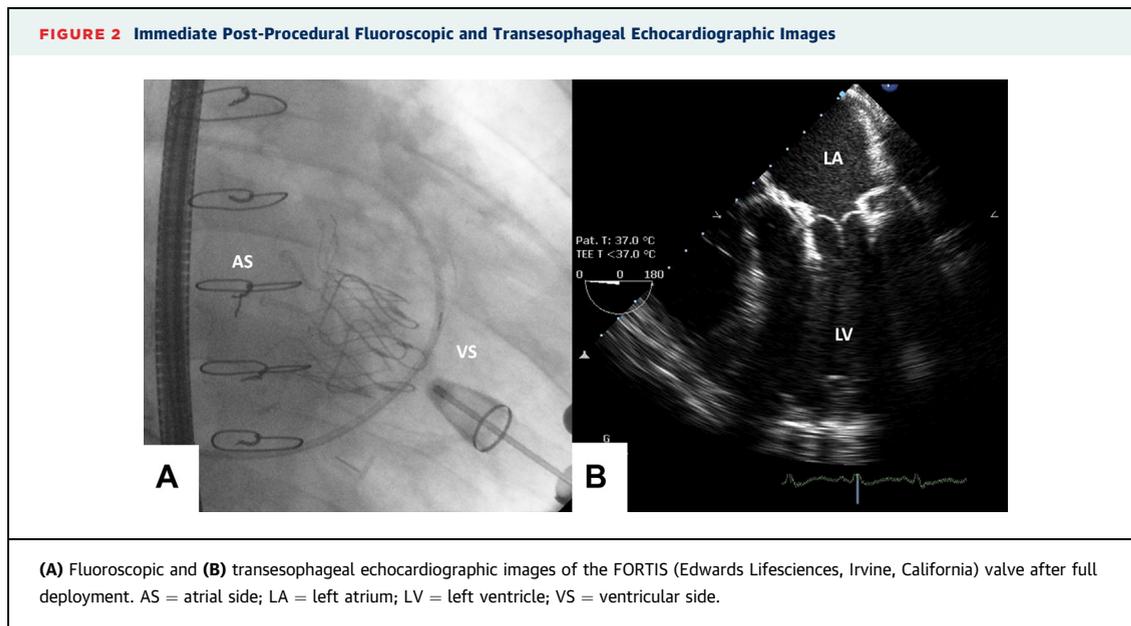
Immediate Post-Procedural Fluoroscopic and Transesophageal Echocardiographic Images
